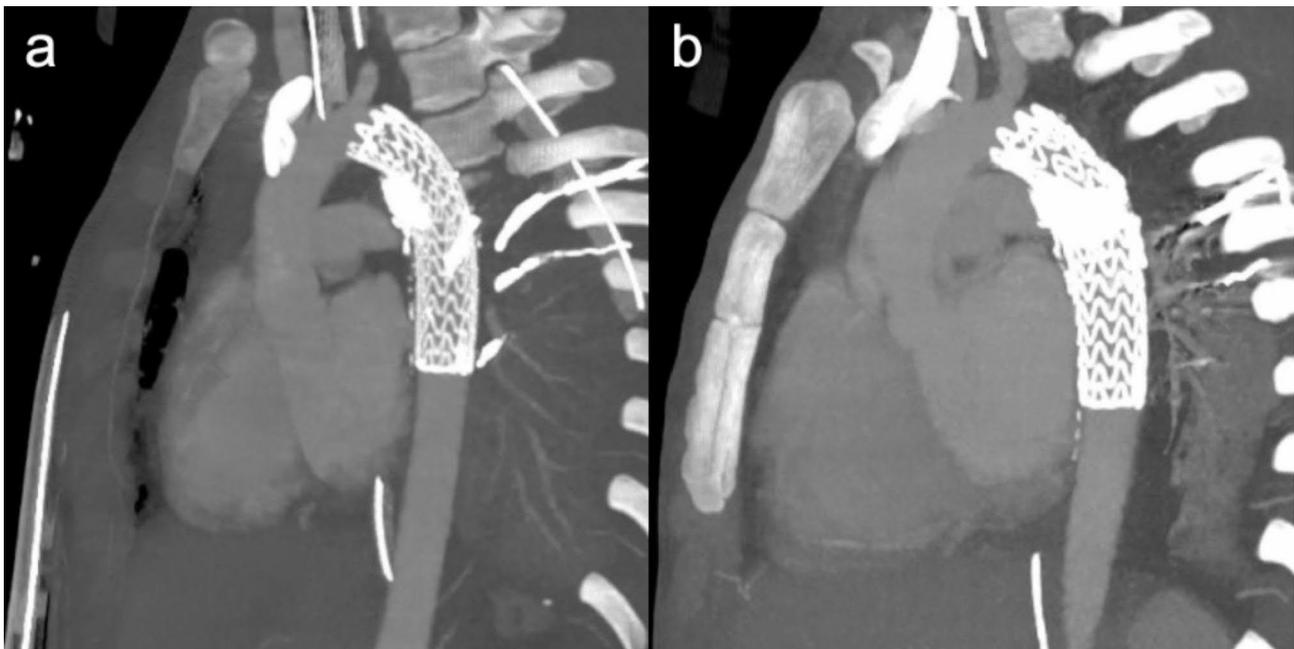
Postoperative computed tomography scans. Scans demonstrated no endoleak on postoperative days 3 (a) and 25 (b)
